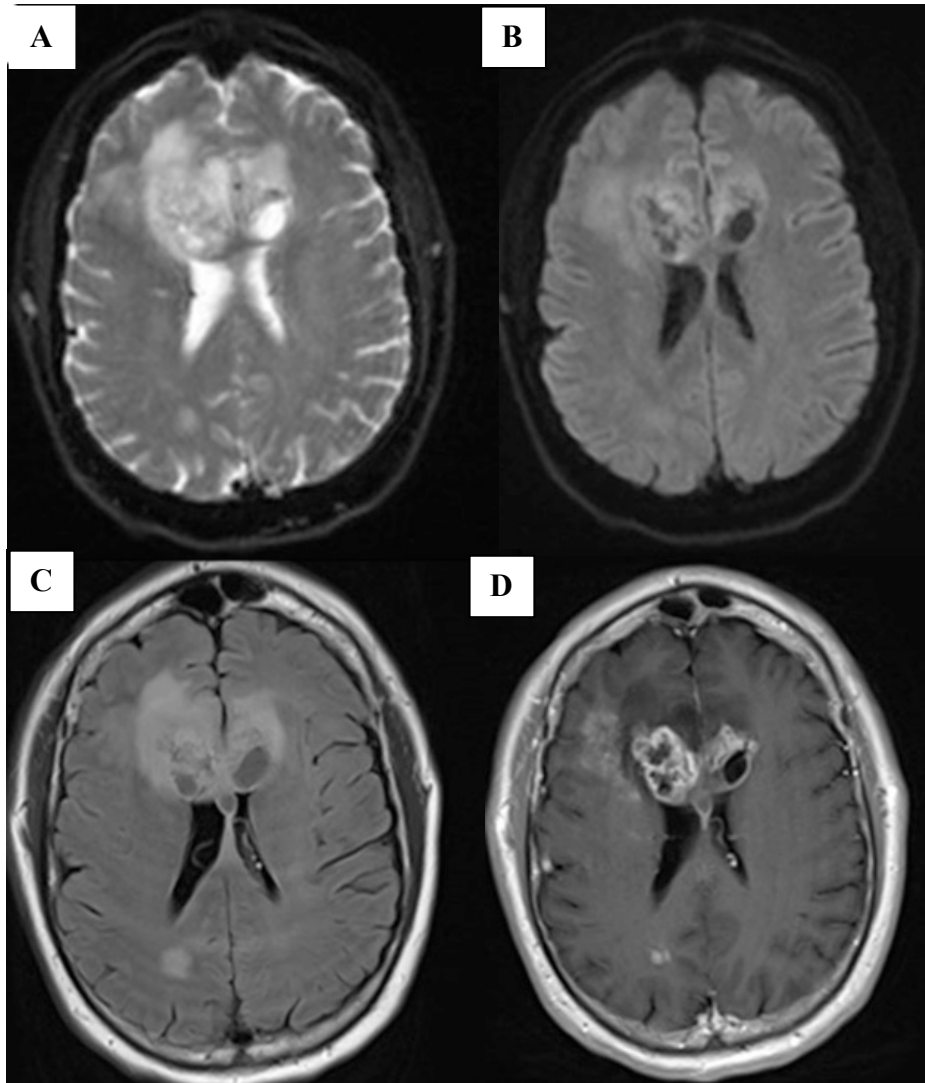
Butterfly glioblastoma imaged with varying MRI sequences. A) T2- weighted, B) T2 -weighted FLAIR, C). T1- weighted, D) T1-weighted contrast enhanced sequences.
